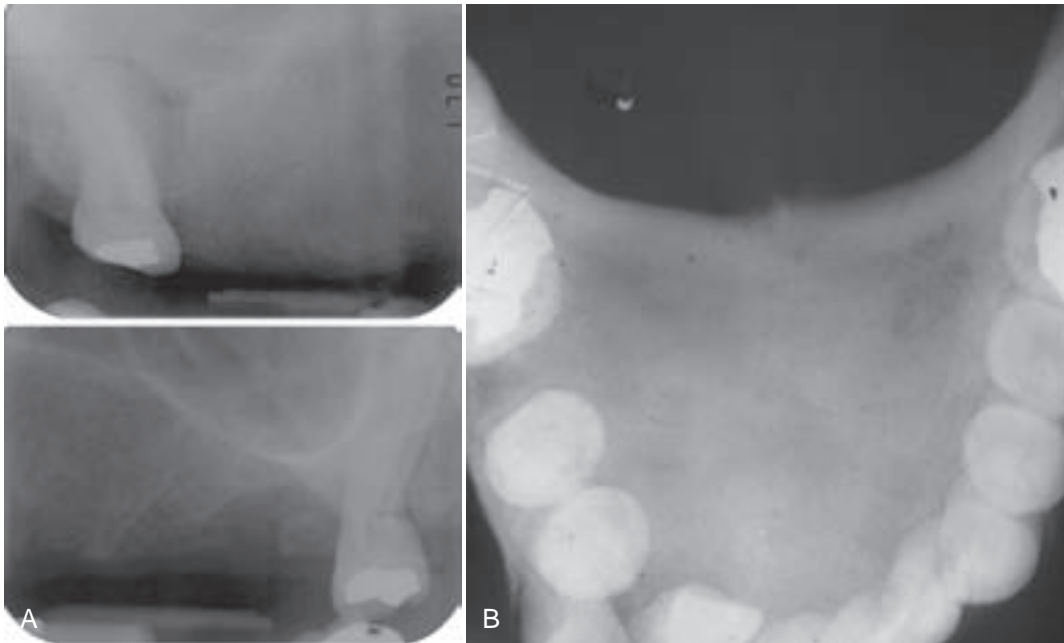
Fibrous dysplasia. A, Periapical films showing ground-glass appearance of the right maxilla (*top panel*) and normal trabeculation on the left (*bottom panel*). B, Ground-glass appearance of mandibular bone. (A, Courtesy of Dr. Bernard Friedland, Harvard School of Dental Medicine, Boston, Mass; B, Courtesy of Dr. Stanley Hirsch, Case Western Reserve University, Cleveland, Ohio.)
